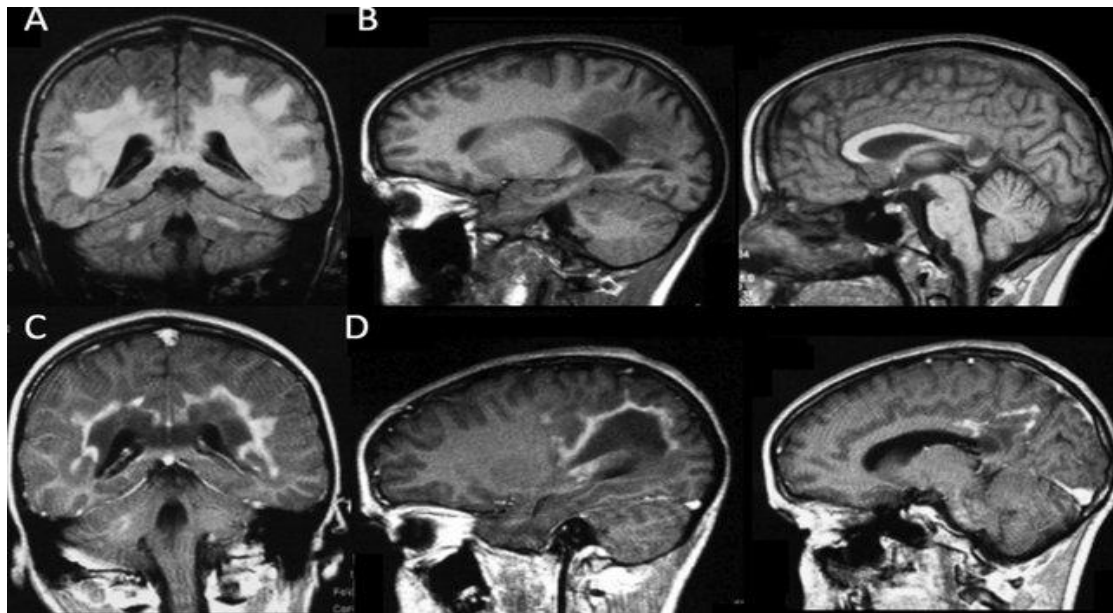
X-linked adrenoleukodystrophy, typical form: A 12 years old boy. MRI shows bilateral involvement of periventricular WM predominantly in the parietal areas, the splenium of the corpus callosum, and cerebellar WM with a peripheral enhancement
